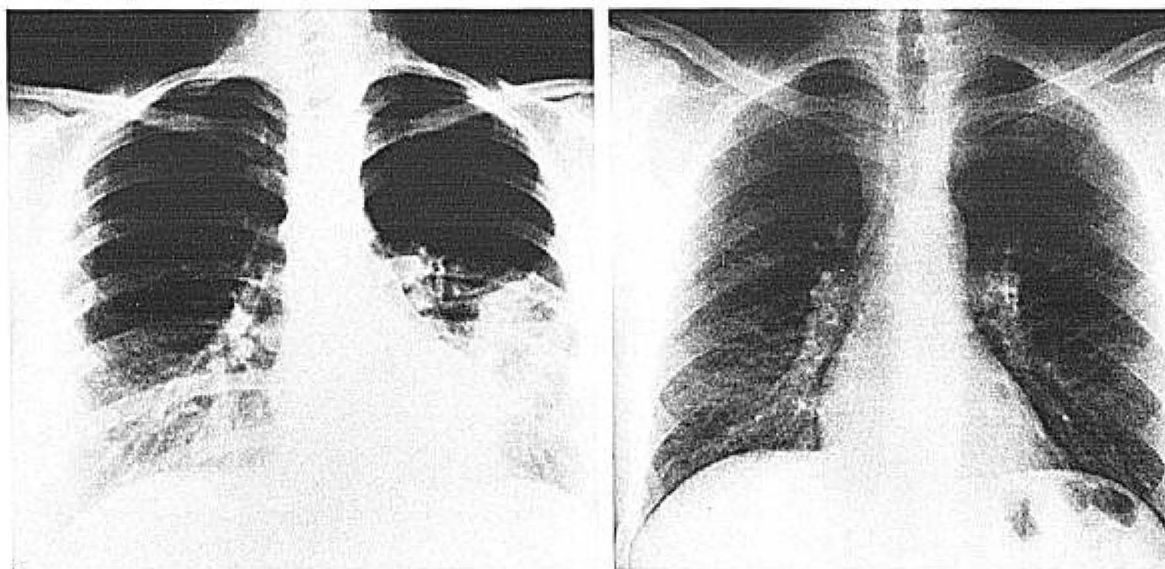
Pneumonia due to *M. pneumoniae*. (Left) Radiograph of an 18-year-old woman showing bilateral, lower lobe (left > right) interstitial, and patchy alveolar infiltrates. (Right) Radiograph of a 43-year-old man with Stevens–Johnson syndrome shows peribronchial and diffuse interstitial infiltrates and hilar adenopathy.
